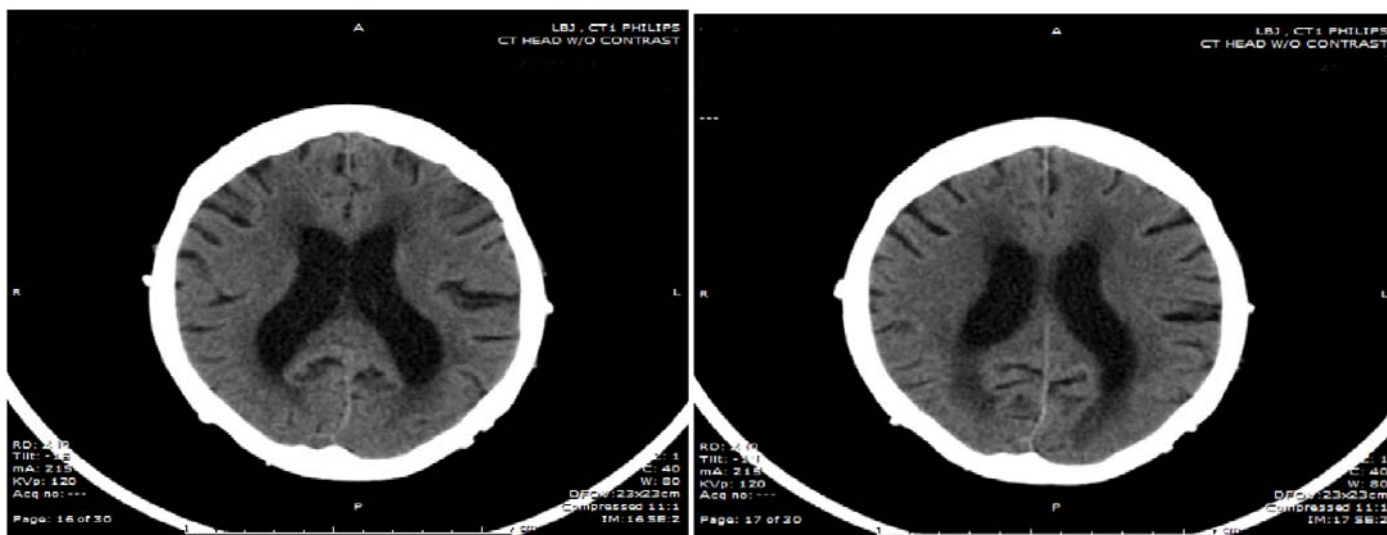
CT scan of brain without contrast revealed enlarged ventricles out of proportion to sulcal atrophy and a left, subacute thalamic stroke.
